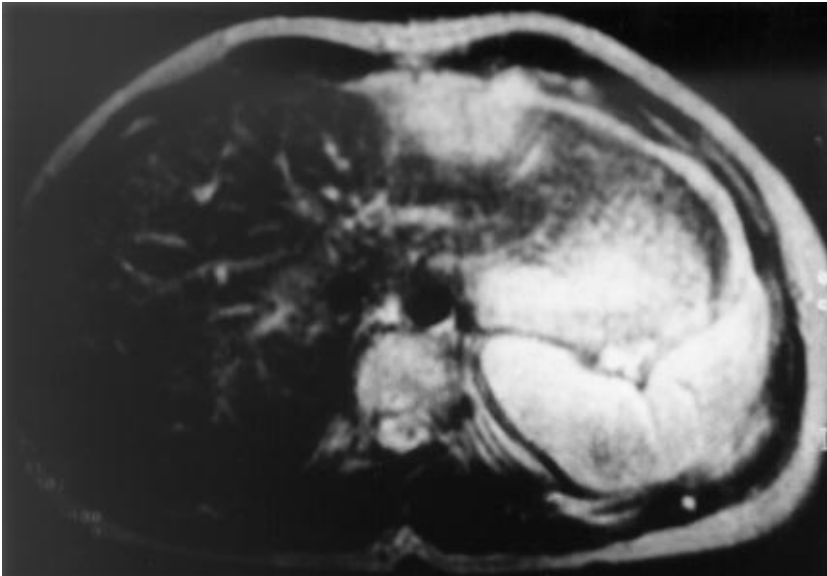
On a T2-weighted axial magnetic resonance image (TR/TE=2000/90 msec), the lesion was markedly hyperintense compared to the liver parenchyma. This signal intensity pattern is not consistent with reported tuberculoma cases in the literature, which commonly exhibited a low signal on both T1- and T2-weighted sequences (4).
